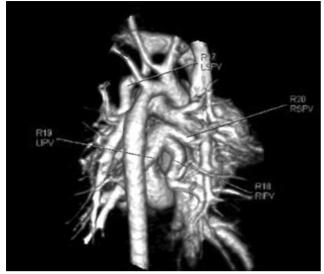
A computed tomography angiography image of mixedtype total anomalous pulmonary venous connection, in which right and left lower pulmonary veins drain to coronary sinus; left upper pulmonary vein connecting to innominate vein via left vertical vein (posterior view).
